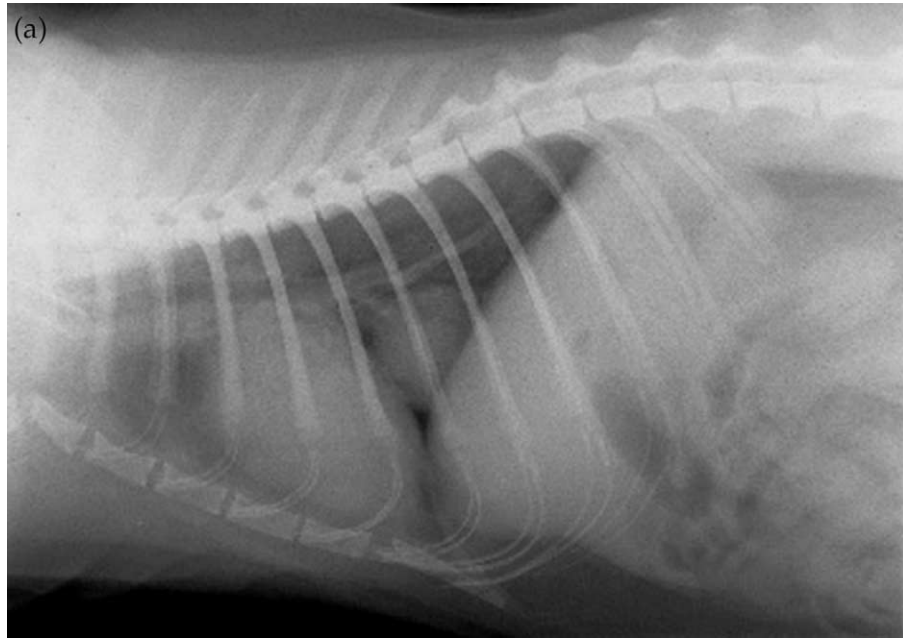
Lateral (A) and ventro-dorsal (B) thoracic radiographs.
